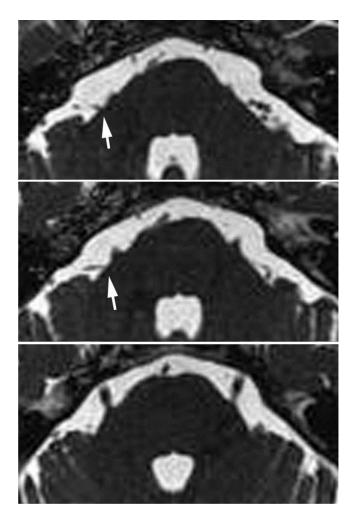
Preoperative consecutive gradient echo magnetic resonance images suggesting contact between the anterior inferior cerebellar artery and the proximal root of the right trigeminal nerve (arrows in upper and middle).
